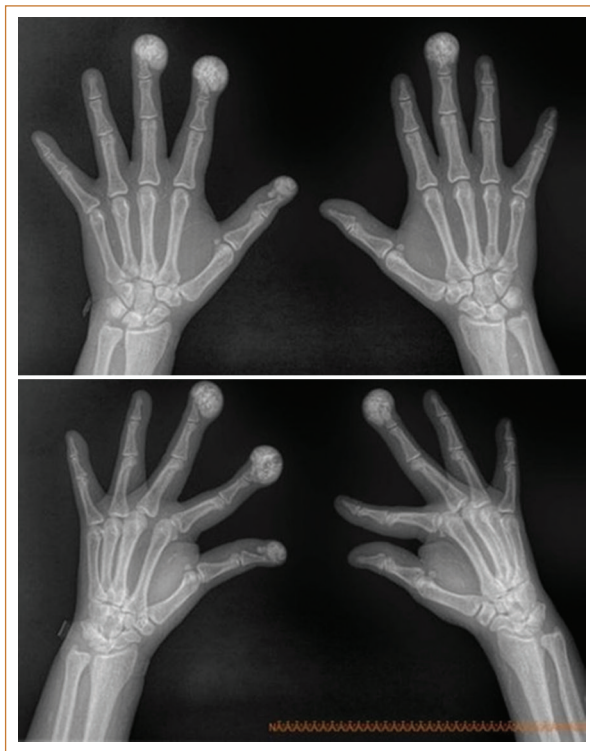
Hand radiographs of the patient (March 12, 2026). Dense nodular calcifications are observed in the periarticular soft tissues of the phalanges of the first, second, and third fingers of the right hand, and the third finger of the left hand, compatible with uremic tumoral calcinosis.
